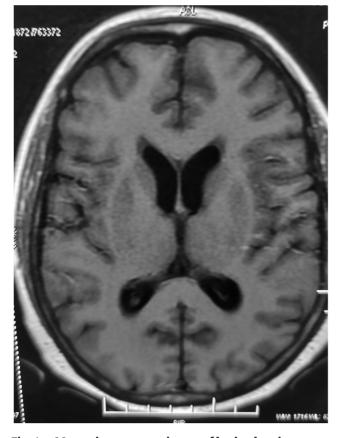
Magnetic resonance image of brain showing normal study.
